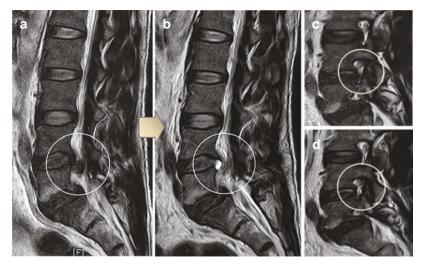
TELD for sequestrated disc herniation with caudal migration. A 51-year-old male patient presented with severe lower extremity radiating pain. Preoperative MRI showed sequestrated down-migrated disc herniation (a)
